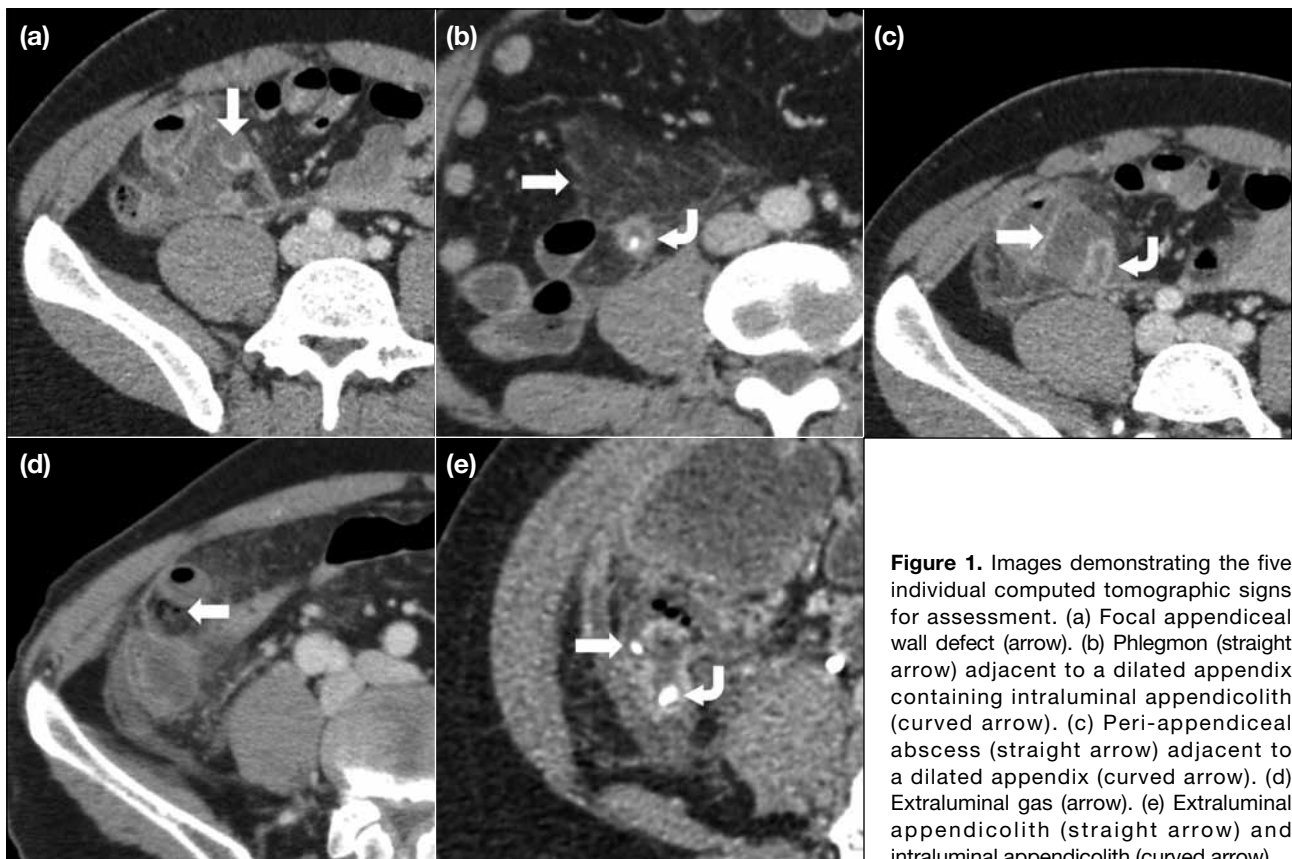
Images demonstrating the five individual computed tomographic signs for assessment. (a) Focal appendiceal wall defect (arrow). (b) Phlegmon (straight arrow) adjacent to a dilated appendix containing intraluminal appendicolith (curved arrow). (c) Peri-appendiceal abscess (straight arrow) adjacent to a dilated appendix (curved arrow). (d) Extraluminal gas (arrow). (e) Extraluminal appendicolith (straight arrow) and intraluminal appendicolith (curved arrow).
